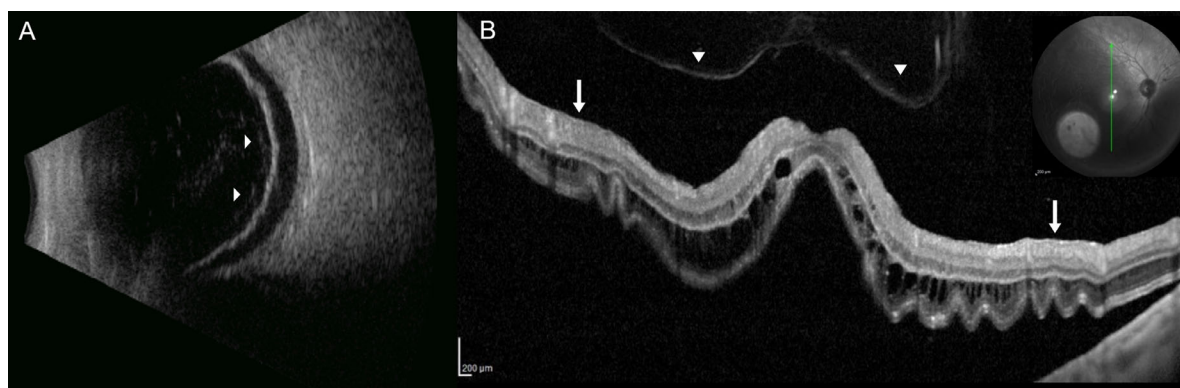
B-scan ultrasonography (US) and optical coherence tomography (OCT) images of an eye with rhegmatogenous retinal detachment and intraoperative evidence of macular and peripheral vitreous cortex remnants. (A) The transverse US image of the mid peripheral retina shows a partially detached vitreous cortex (arrowheads) running parallel to the detached retina, the "lining sign." (B) The OCT scan shows a detached vitreous cortex (arrowheads) and a preretinal hyper-reflective layer on the inferior and superior aspect of the macula (arrows). The green line on the infrared image shows the level of the OCT scan.
